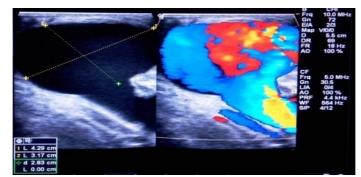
Color Doppler ultrasound: shows color swirl of large pseudoaneurysm at the basilic vein
